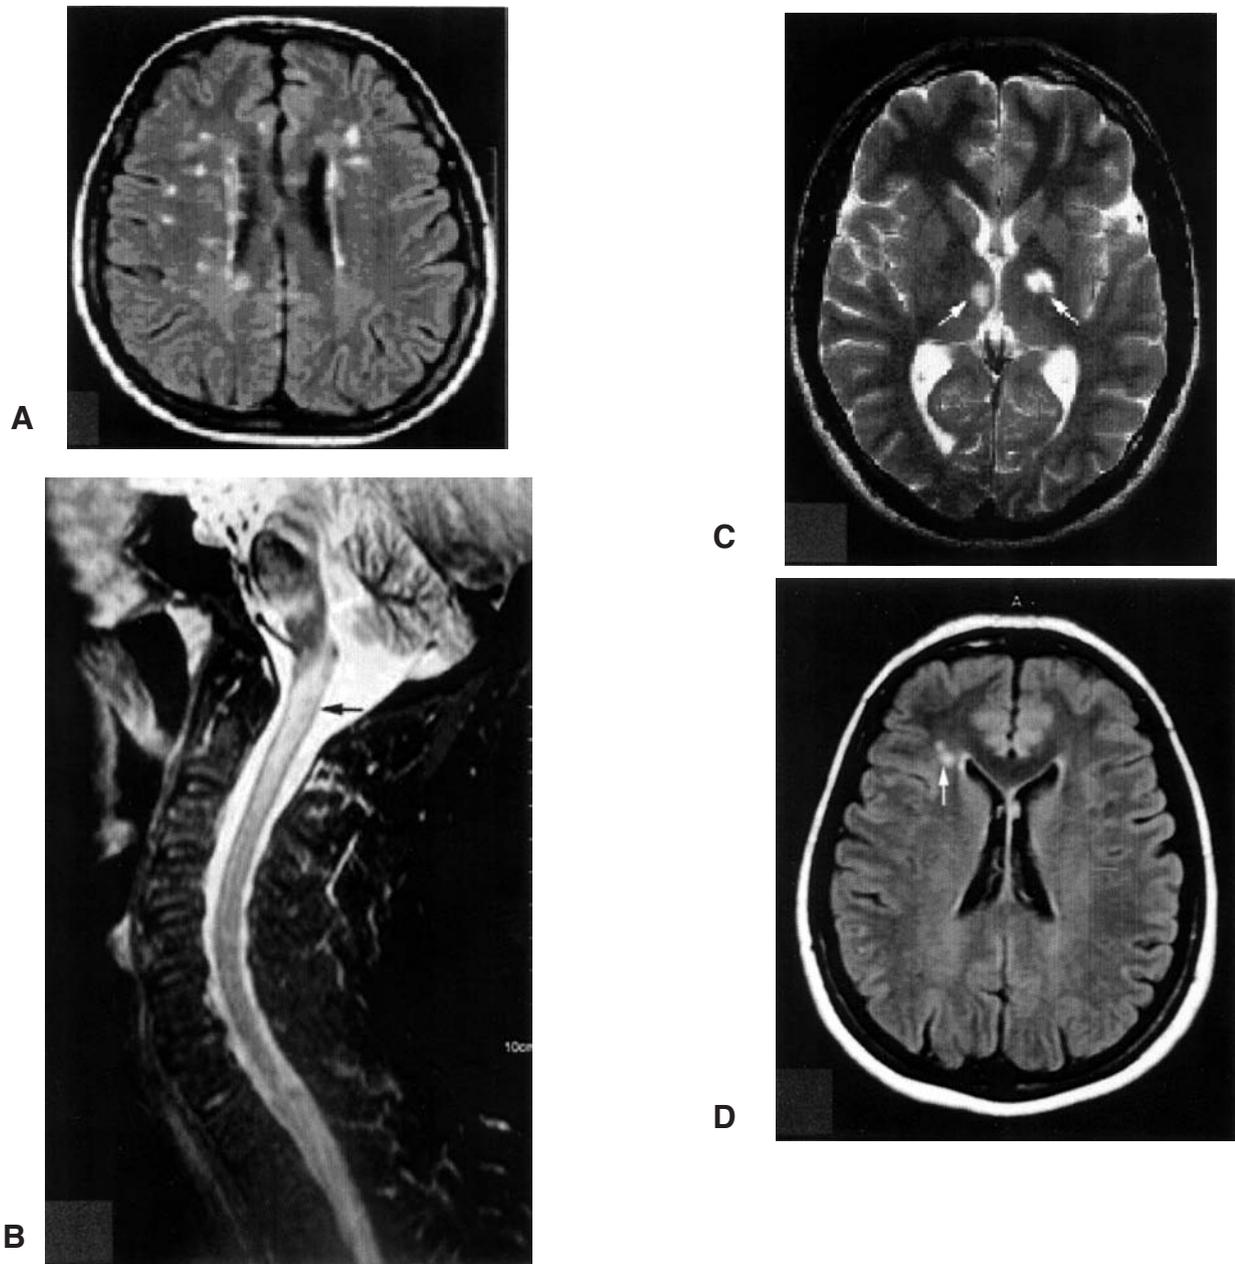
A. MS-like lesions: axial FLAIR MRI scan of brain reveals multiple focal hyperintense lesions in the white matter of both cerebral hemispheres. Similar abnormalities were also present in other tomographic sections (not shown). B and C. Vasculitic lesions: (B) Sagittal T2-weighted image of the cervical spine shows an abnormal area of increased signal intensity in the proximal cervical cord involving both gray and white matter (arrow). (C) Axial T2-weighted image of brain of the same patient. There are 2 small-vessel ischemic lesions in the left globus pallidus and in the right thalamus (arrows). D. Nonspecific brain lesions: axial FLAIR image of the brain reveals 2 punctate lesions of abnormal increased signal in white matter of the right frontal lobe (arrow).
